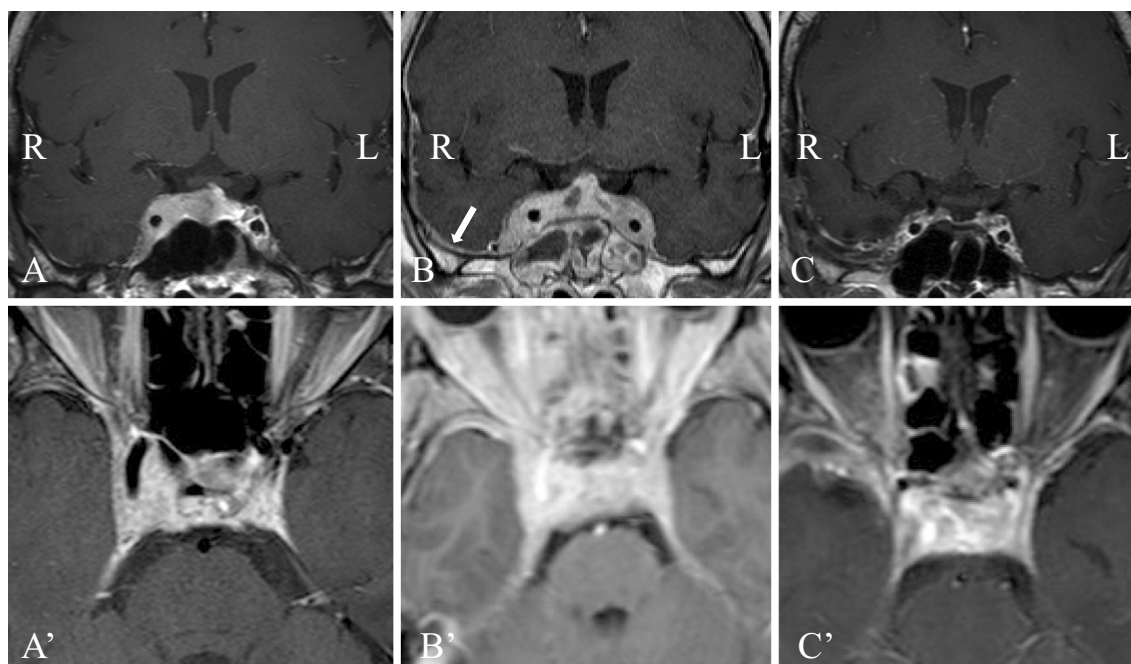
A-A': Coronal (A) and axial (A') sections of contrast-enhanced magnetic resonance imaging (MRI) before the initial surgery. A mass is seen extending from the right cavernous sinus to the pituitary region. B-B': Coronal (B) and axial (B') sections of contrast-enhanced MRI before the second surgery. A new mass is evident in the left cavernous sinus. White arrow indicates the dura matter adjacent to the cavernous sinus that is hypertrophied and enhanced compared with the previous MRI (A). C-C': Coronal (C) and axial (C') sections of contrast-enhanced MRI obtained 1 year after treatment was begun. The tumor has completely disappeared.
